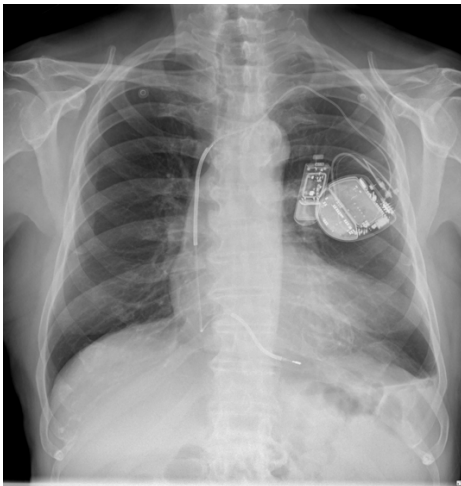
Chest X-ray at admission. Note the single-chamber implantable cardioverter-defibrillator and previously implanted loop recorder
